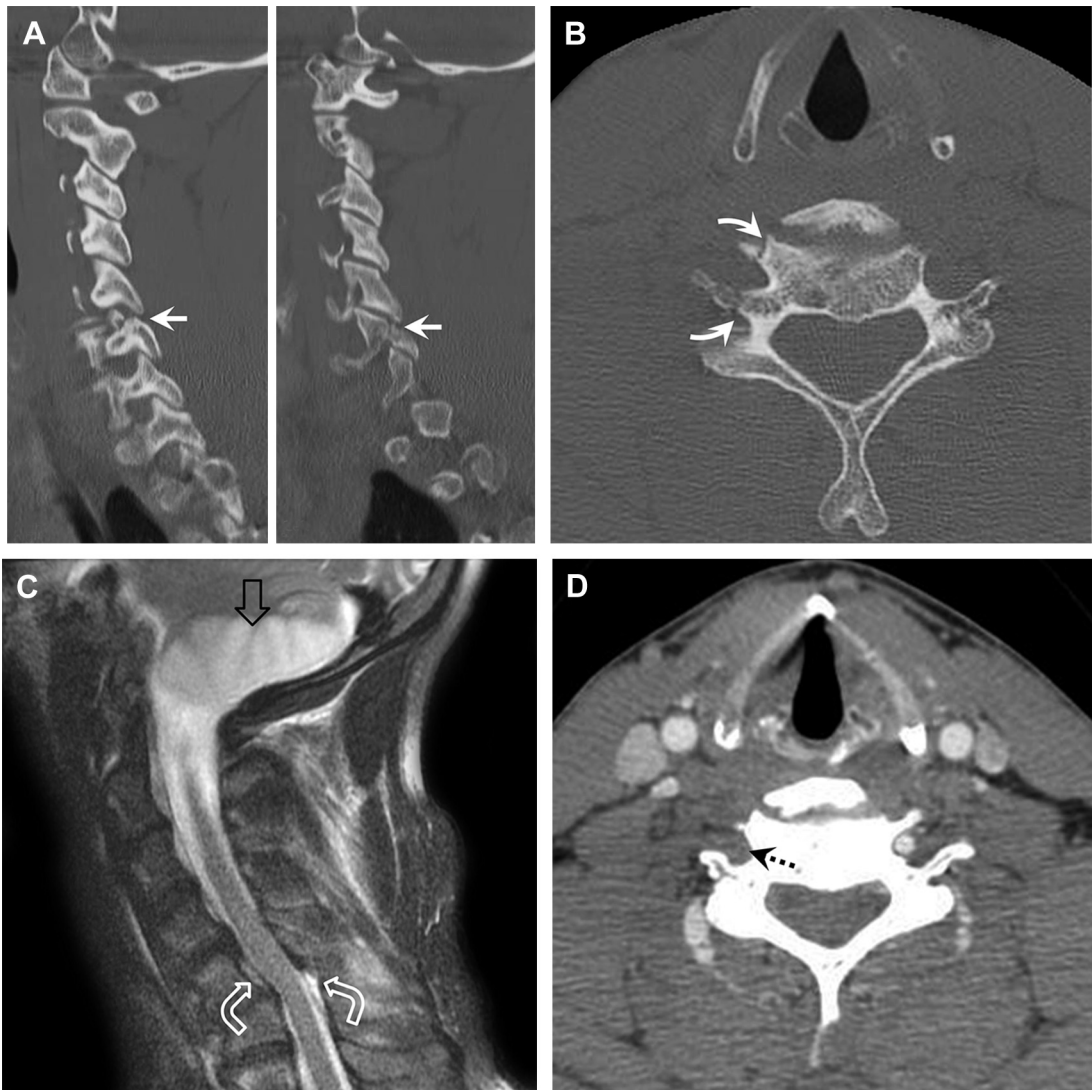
Right vertebral artery occlusion and “asymptomatic” posterior inferior cerebellar artery infarct. Sagittal (A) and axial (B) CT images of a chiropractor who sustained a motor vehicle accident demonstrate fractures (arrows) of the right superior articular facet and lateral mass of C5. There is involvement of the C5 foramen transversarium (curved arrows). There is no subluxation on the sagittal images. (C) A sagittal T2-weighted MR imaging scan was obtained to rule out ligamentous injury. There is new C5–C6 vertebral subluxation and evidence of ligamentous injury (curved open arrows). An “asymptomatic” posterior inferior cerebellar artery infarct (open arrow) is present. (D) Axial CTA image confirms occlusion of the right vertebral artery (dashed arrow).
